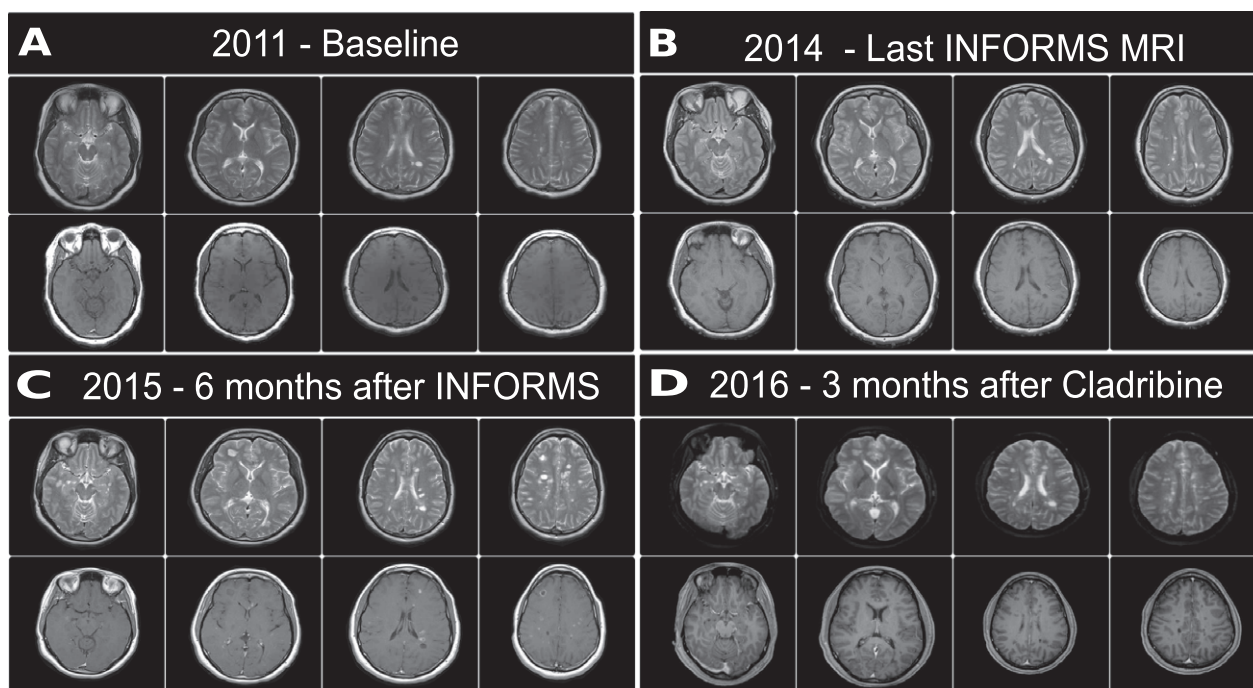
(A) Baseline MRI taken before entrance to INFORMS study. (B) Last MRI taken at the end of INFORMS study. (C) MRI taken 6 months after suspending Fingolimod and during the clinical relapse. (D) MRI taken 3 months after receiving treatment with Cladribine.
